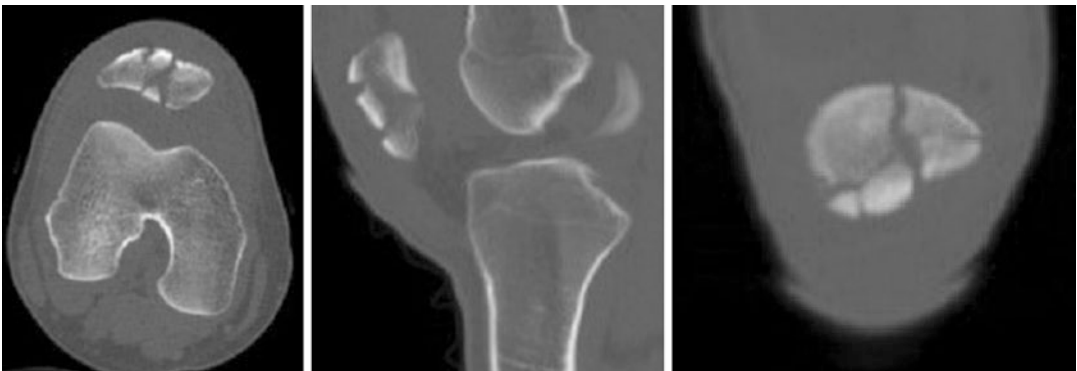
Preoperative axial, sagittal, and coronary CT views
